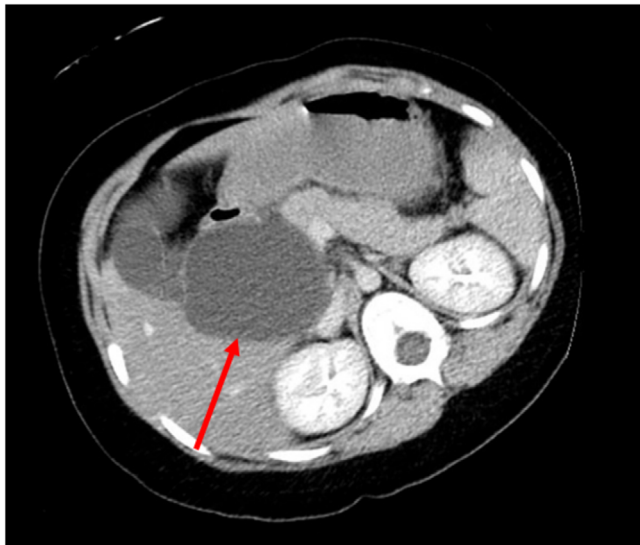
CT image of choledochal cyst in transverse view
